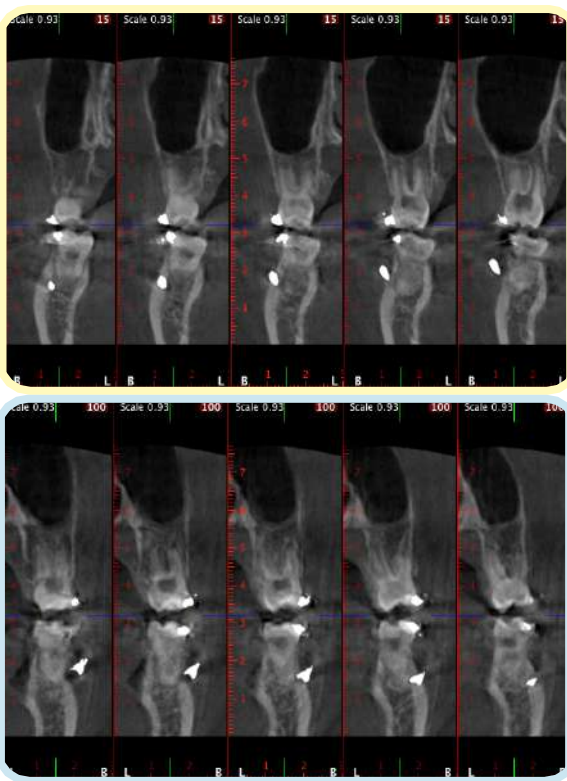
CBCT slices in the 16th month show the E-A insertion of mandibular shelf bone screws on the right (upper) and left (lower) sides.
